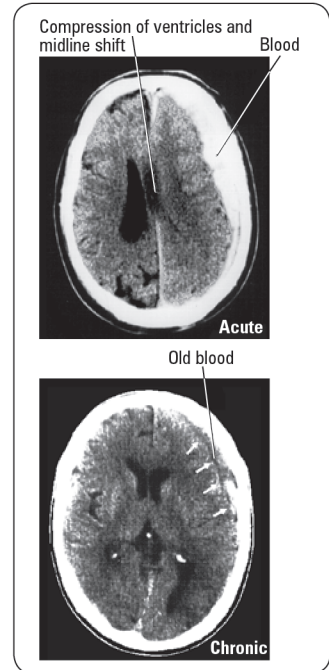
Subdural hematoma on CT
